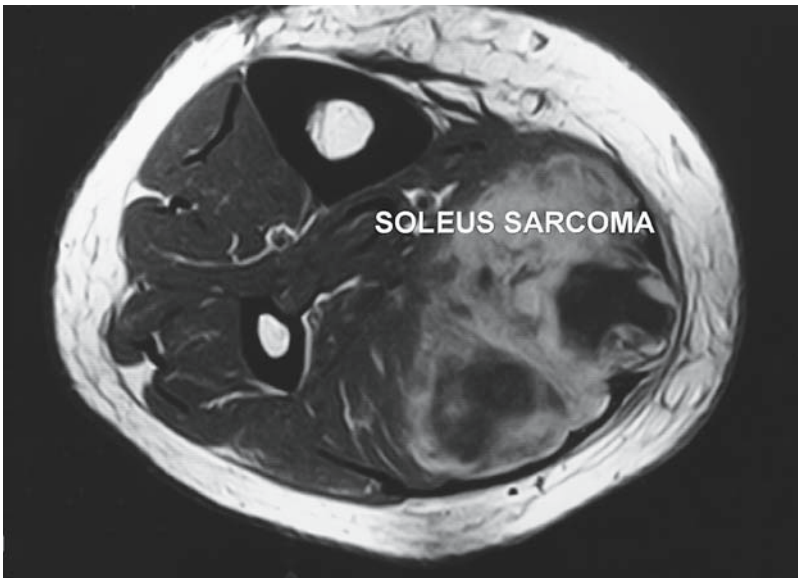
Sarcoma of leg. MRI scan demonstrates a large soft tissue mass of the posterior leg (soleus muscle). This lesion has compressed the surrounding anatomical structures and has a heterogeneous appearance.
